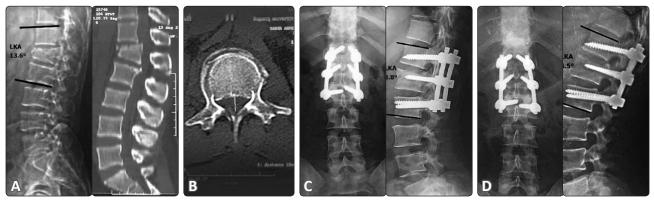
Male patient, 32 years old, with A3 fracture of L1. He was treated by short-segment fixation from T12 to L2 with intermediate screw. Preoperative (A) plain X-rays (LKA 13.6°, AVHL% 34.1%); (B) CT scan. Postoperative (C) plain X-rays (LKA 3.8°, AVHL% 10.9%); (D) final follow-up plain X-rays (LKA 4.5°, AVHL% 12.1%).
